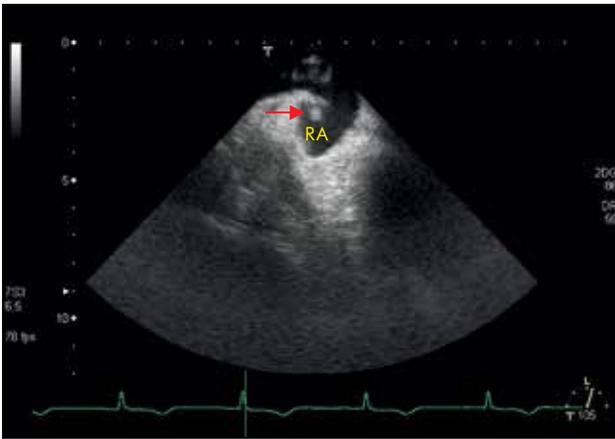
Transesophageal echocardiography. Bicaval view. Thick atrial septum proximal to the fossa ovalis (arrow). LA – left atrium, RA – right atrium
